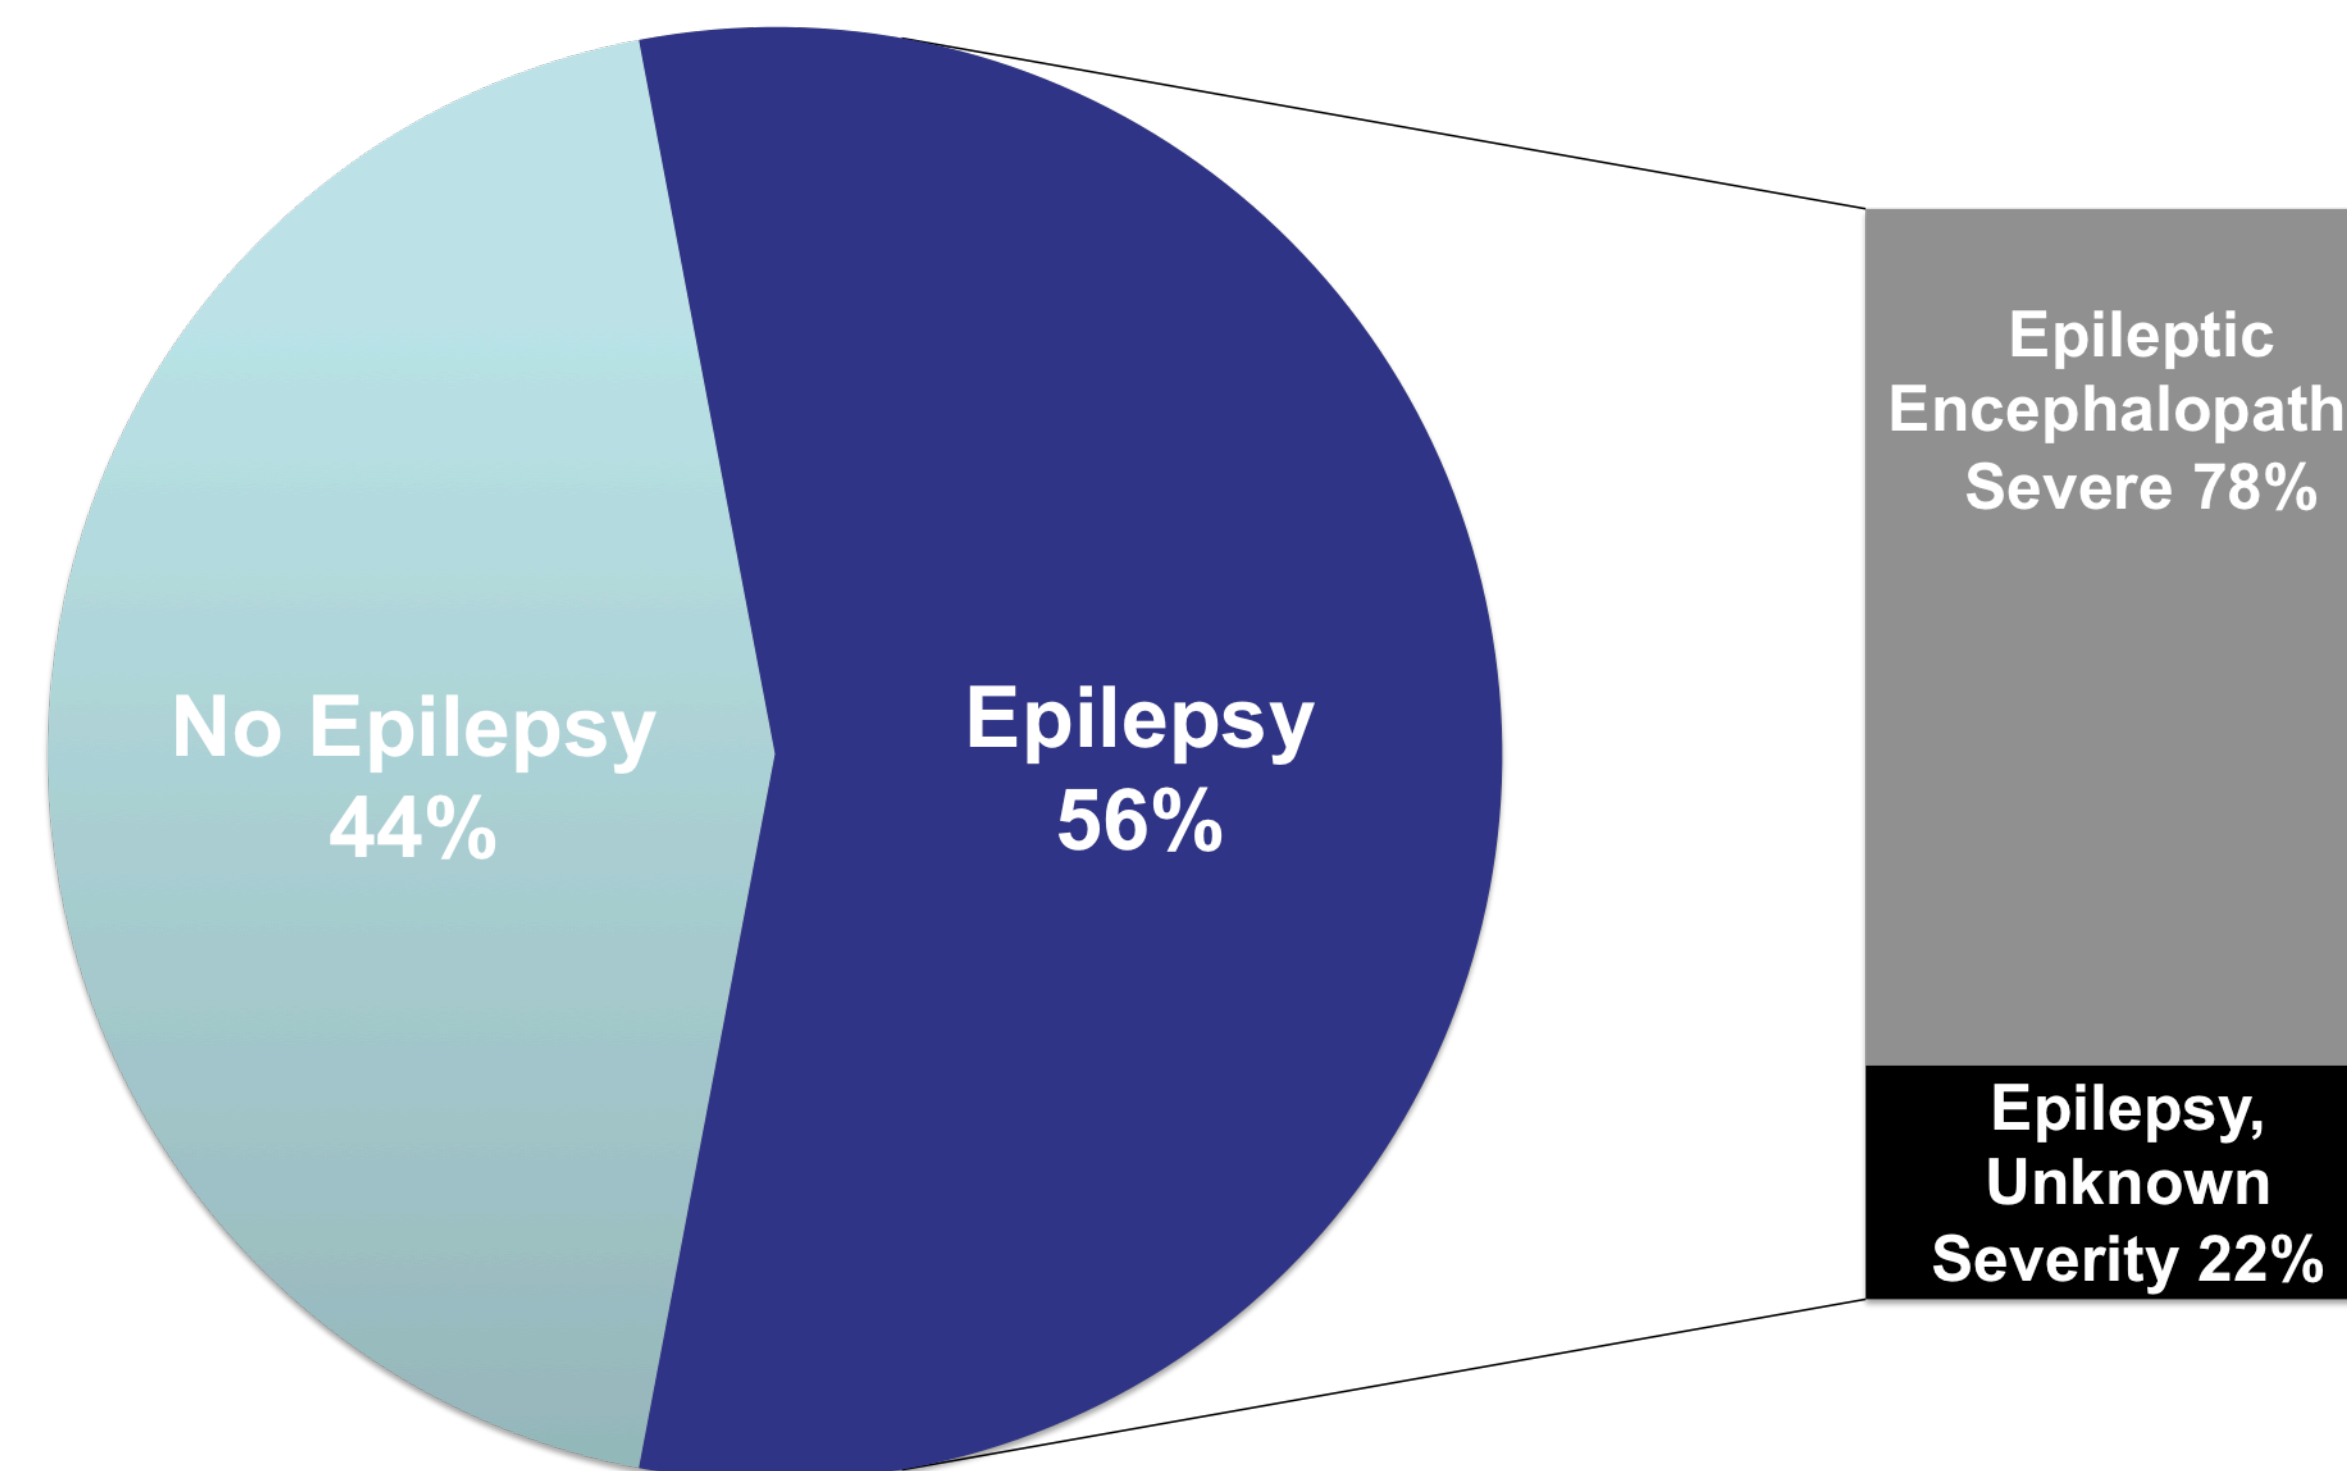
Nine subjects (56%) had epilepsy which was refractory in 7/9 (78%) of them. The degree of seizure control and severity could not be assessed in 2/9 subjects. Brain MRI findings included parenchymal volume loss, non-specific signal abnormalities, simplified gyral pattern, callosal hypoplasia, and cortical dysplasia.
